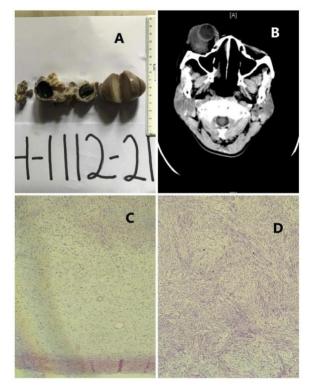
Show the cut sections through the eyeball showed unremarkable anterior and posterior chambers and an ovoid that is nodular gray-white and in appearance (A). Brain CT (B) showing a homogenous soft tissue mass (HU=32) measuring 4.5cm x 2.6cm x 2.3cm (CC x AP x TR). Sections from (C & D) showed an encapsulated tumour composed of spindle cells proliferation disposed in whorls and swirling pattern forming concentric circles with intervening collagen surrounding thin wall vascular channels in areas (X 4 and X 10 respectively).
